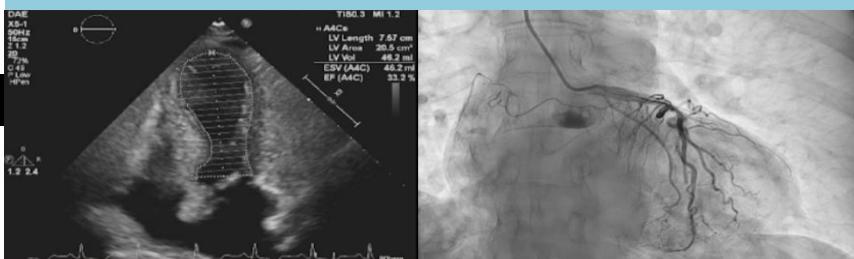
Apical ballooning of left ventricle on echocardiography
